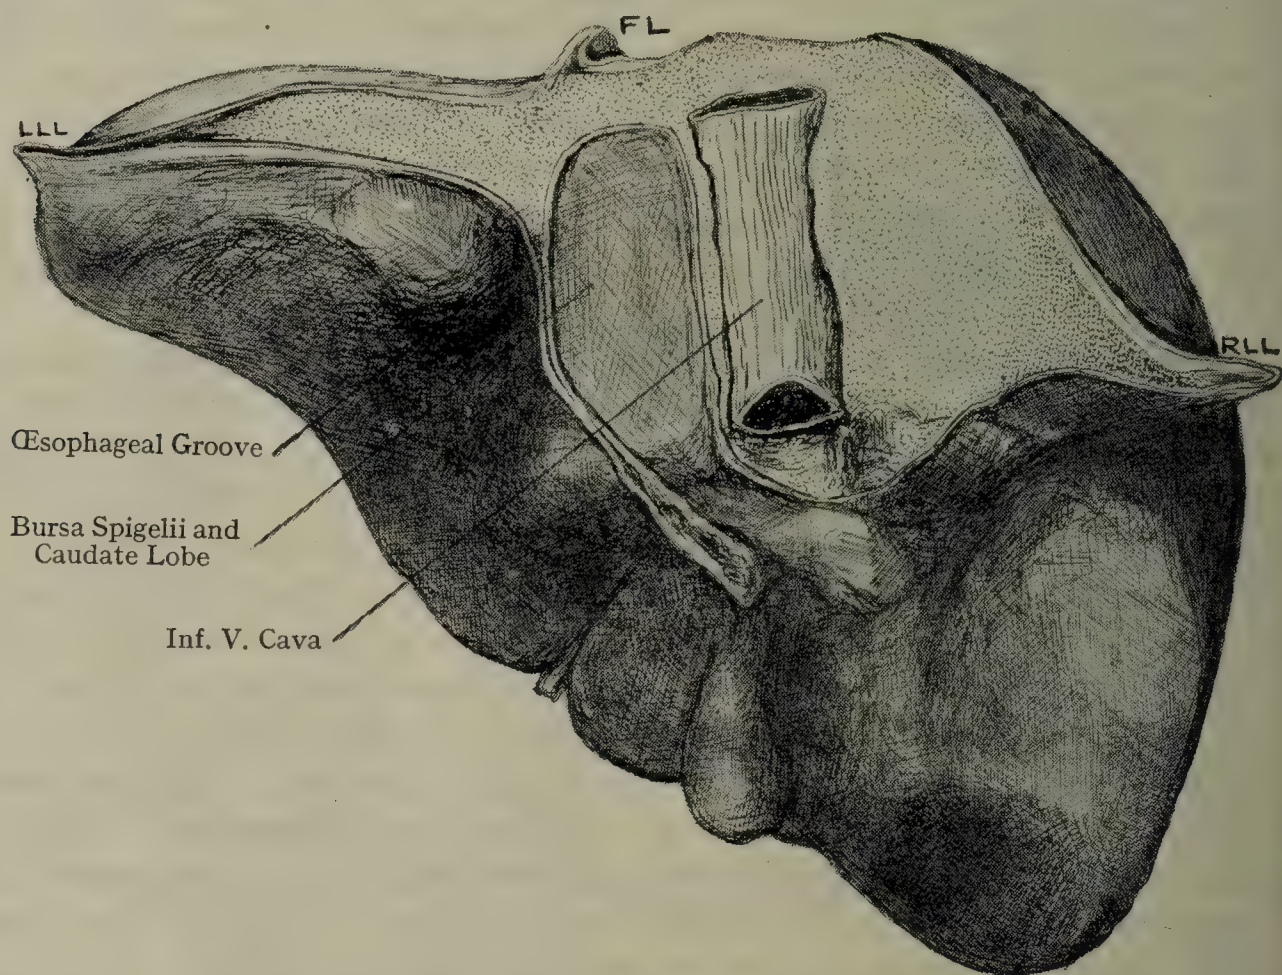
POSTERIOR ASPECT OF LIVER, SHOWING BARE AREA.
